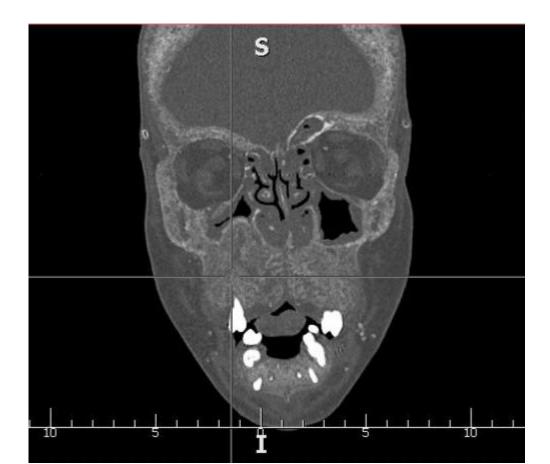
CT scan of head showing deformation of maxilla.
